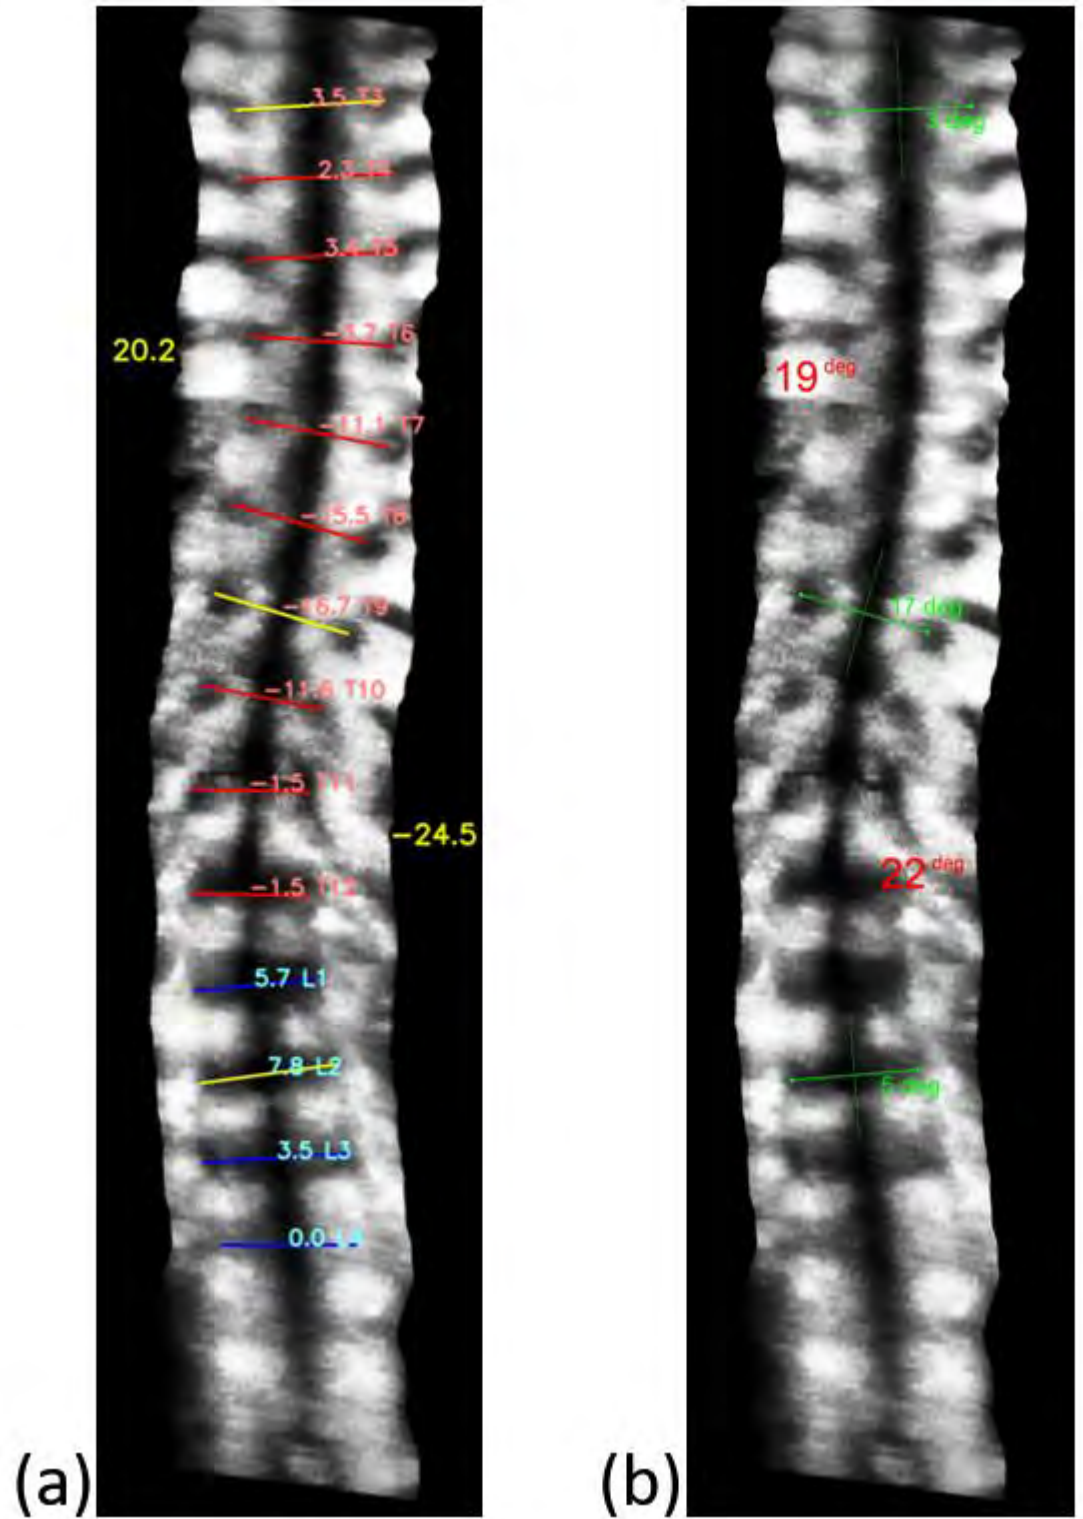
3D ultrasound image of same subject measured by (a) the automatic method and (b) the manual method².
